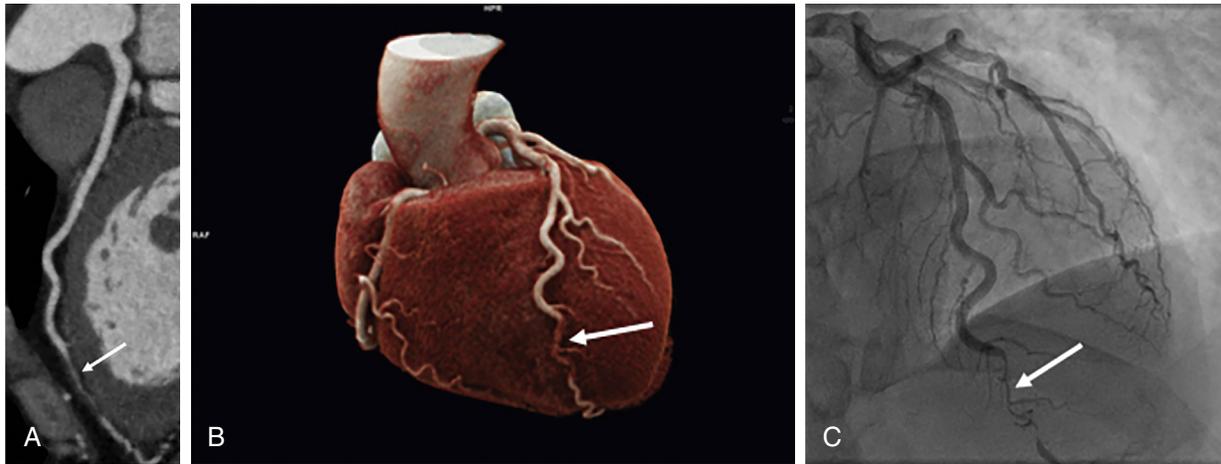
Example of spontaneous coronary artery dissection diagnosed by coronary computed tomography angiography. Images show dissection of distal left anterior descending artery (white arrow) on curved multiplanar reformatting image (A), three-dimensional cinematic volume-rendered image (B), and invasive angiography (C). (Courtesy of Dr. Sumit Gupta, Brigham and Women's Hospital, Boston.)
